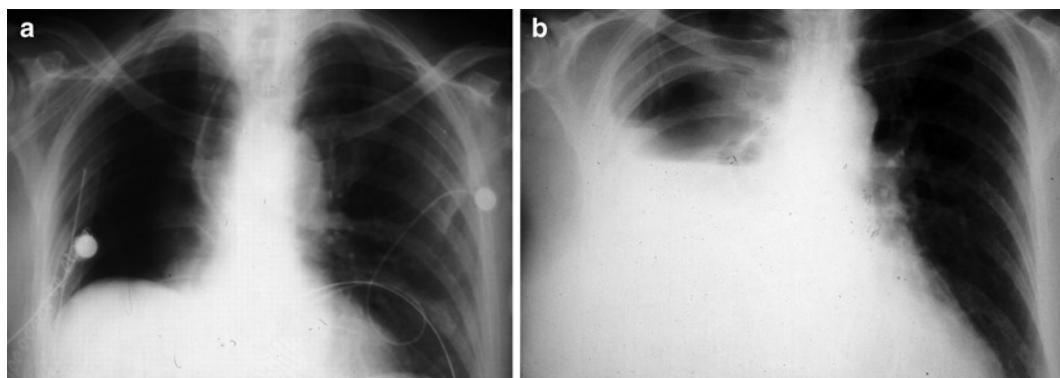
(a) Postoperative chest X-ray of a 65-year-old patient day 1 following a right pneumonectomy. (b) The same patient on postoperative day 7. The fluid volume in the right hemithorax has decreased from the previous day (day 6, not shown) and there are new multiple air-fluid levels.
